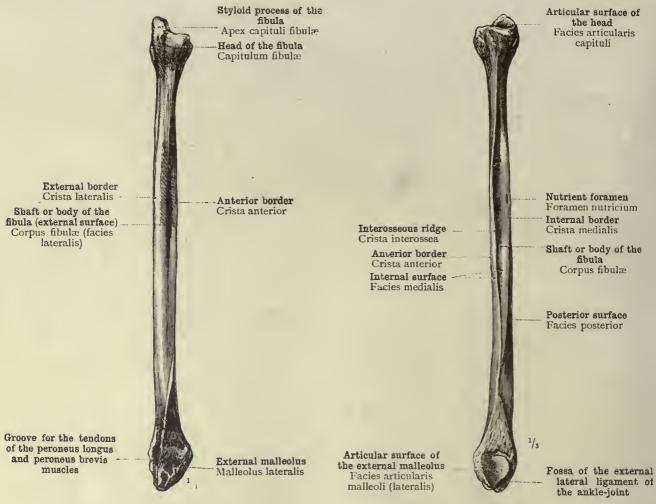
EXTERNAL ASPECT.
